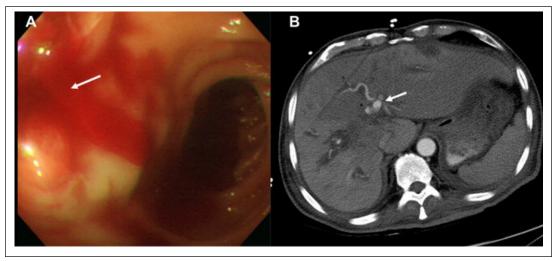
Active hemorrhage and the site and appearance of the hemorrhage noted on multi-detector CT images
